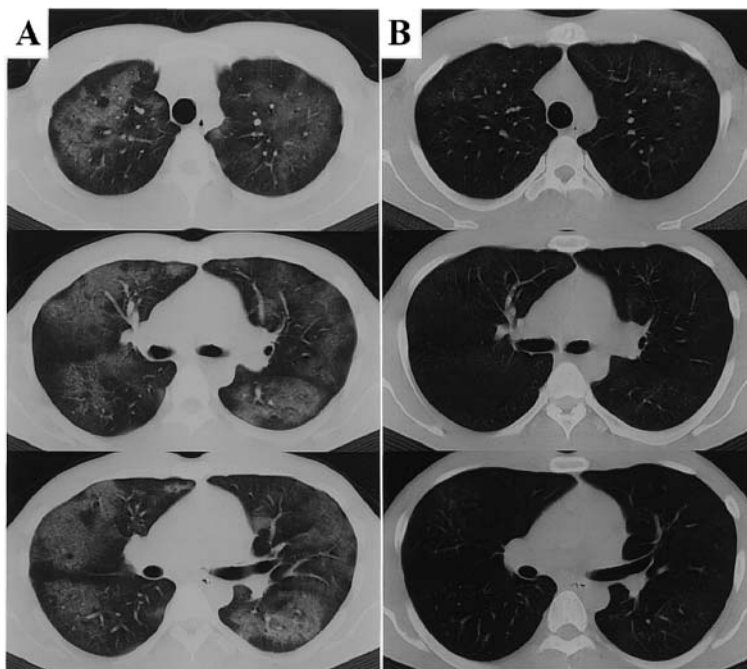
CT scan of the chest of Case 4.
